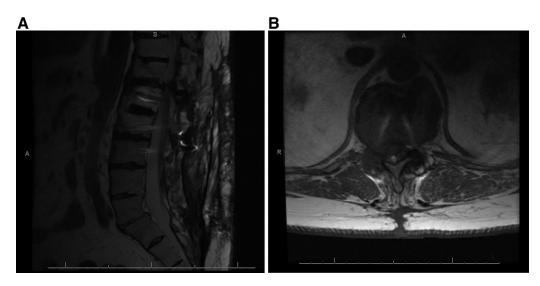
A, 6B Sagittal (6A) and Axial (6B) view MRI of the lumbar spine without contrast demonstrating a large facet cyst at T12–L1 with lateral recess stenosis and compression of the spinal cord.
